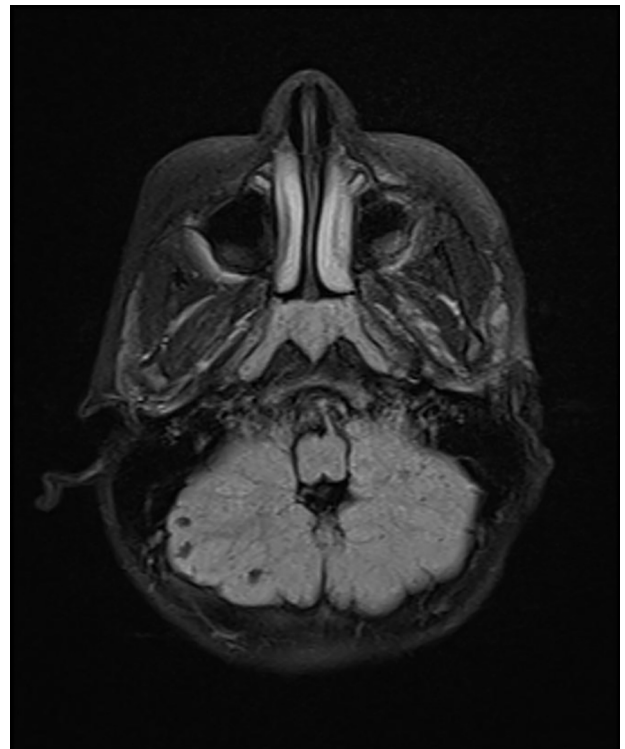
Brain MR images show cerebellar cyst. MR indicates magnetic resonance.
